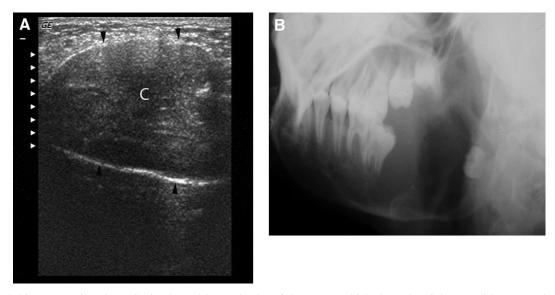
Subject 17: Unilocular. US (A) showed internal echo of the tumor, which showed mainly on solid content; there is no obviously bony septa inside the compartment; the boundary of the tumor is clear (*arrowheads*). The unilocular was observed with panoramic radiography and the lesion's boundary is clear (B).
